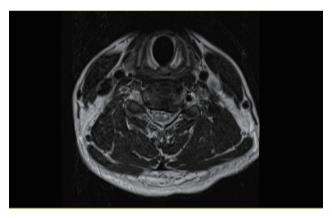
"Owl's eye sign" on T2 weighted axial MRI at C5-C6.
